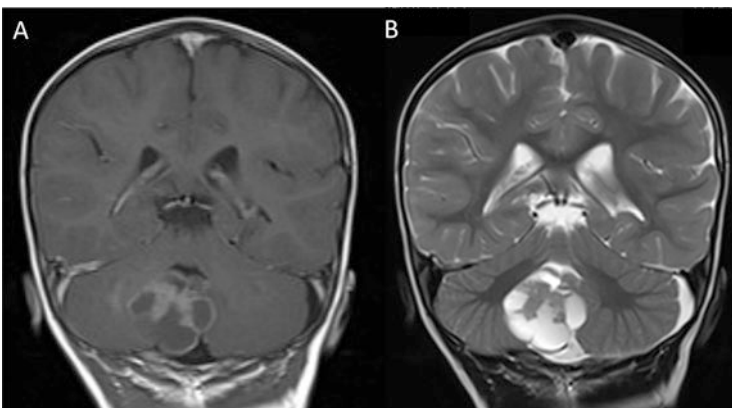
17-month male with a 3.5 cm atypical teratoid/rhabdoid tumor, localized to the right cerebellar hemisphere with a central solid component and several cystic loculations. (a) T1 post-gadolinium. (b) T2-weighted image
